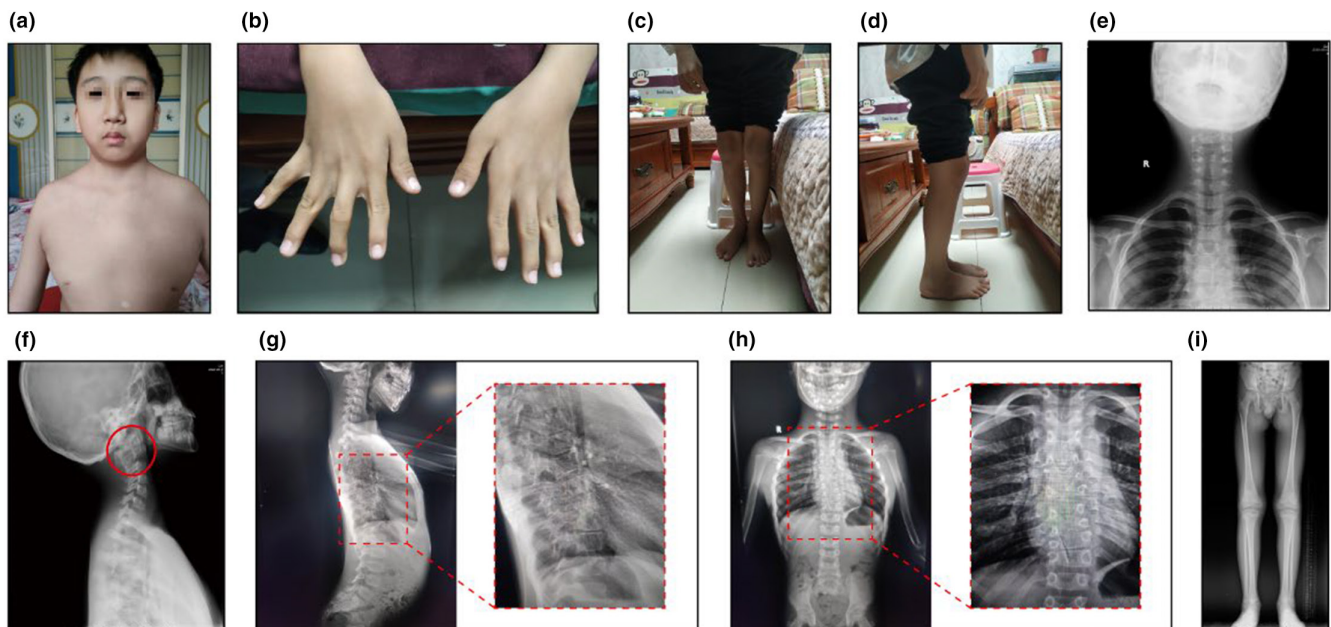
The clinical manifestations of the proband in this study. (a) A frontal view of the patient: triangular face, low-set ears, thick and slightly arched eyebrows, webbed neck, barrel-shaped chest, and sloping shoulders. (b) Hands: interphalangeal joint contracture. (c) and (d) The front and side of the lower limbs: flexion state in knees. (e) and (f) X-ray of the front and side of the cervical vertebra: atlantoaxial fusion (red circle). (g) and (h) X-ray of the front and side of the trunk: scoliosis, fusion of vertebrae. (i) X-ray of the front side of the lower limb: no significant abnormality.
